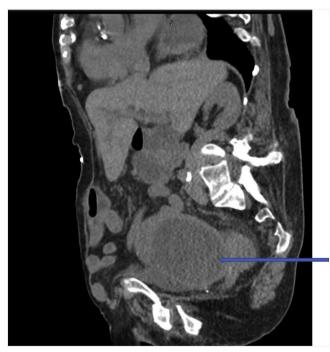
Blue arrow. Large complex cystic pelvic mass on CT pelvis sagittal view.
